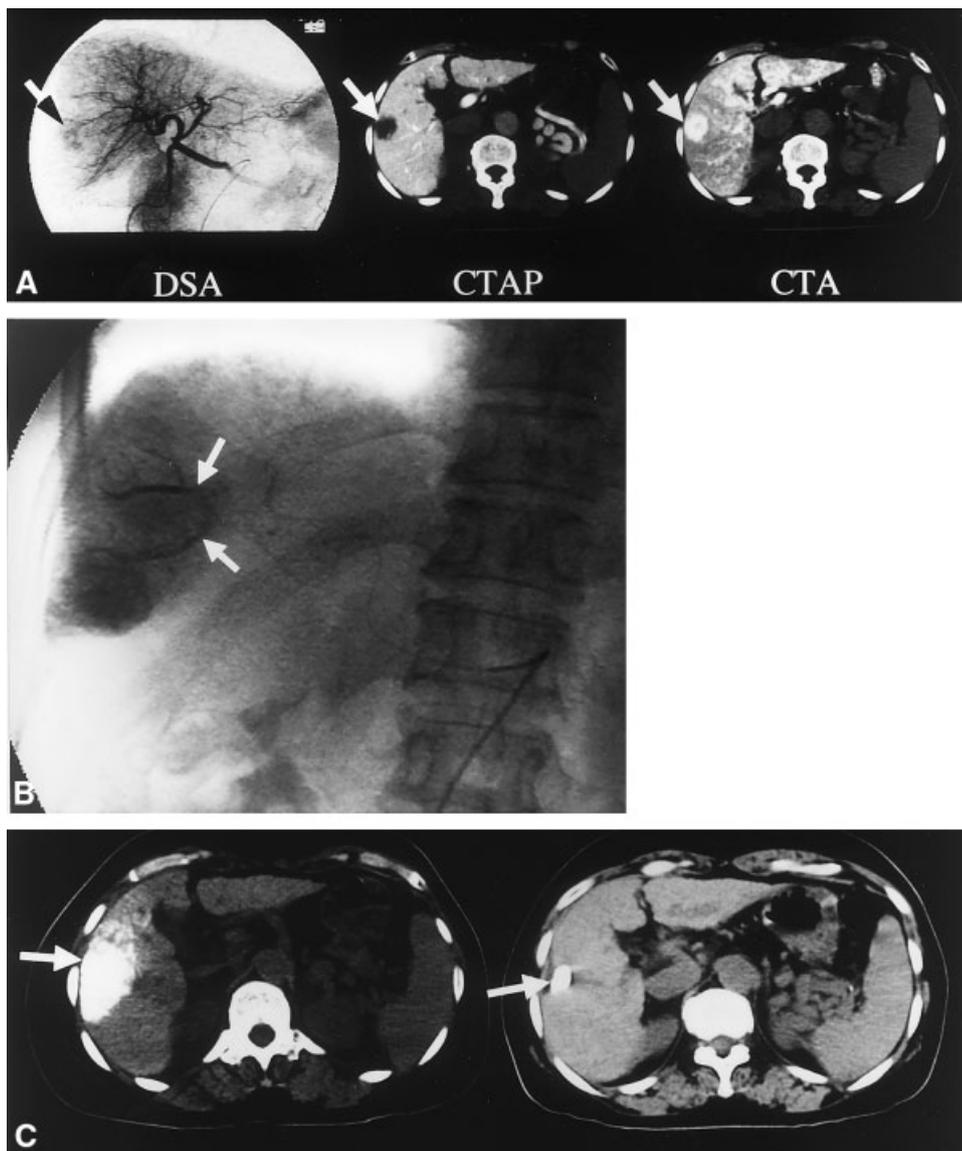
In this 66-year-old woman with C-viral cirrhosis, a 20-mm lesion, typical of hepatocellular carcinoma (HCC) was found in the fifth liver segment in March, 2001. (A) Digital subtraction arteriography (DSA), helical computed tomography (CT) scan during hepatic arteriography and catheterization of the mesenteric artery with 20 μ g of prostaglandin E₁ (CTAP), and helical CT during hepatic arteriography (CTA) all showed a typical small HCC (arrows). (B) During embolization, portal vein branches were opacified retrogradely (lower arrow) and antegradely (upper arrow). (C) Left: CT scan showing deposition of lipiodol in and around the lesion (arrow) immediately after embolization. Right: CT scan 8 months later. The lipiodolized lesion (arrow) has shrunk along with the surrounding liver parenchyma.
